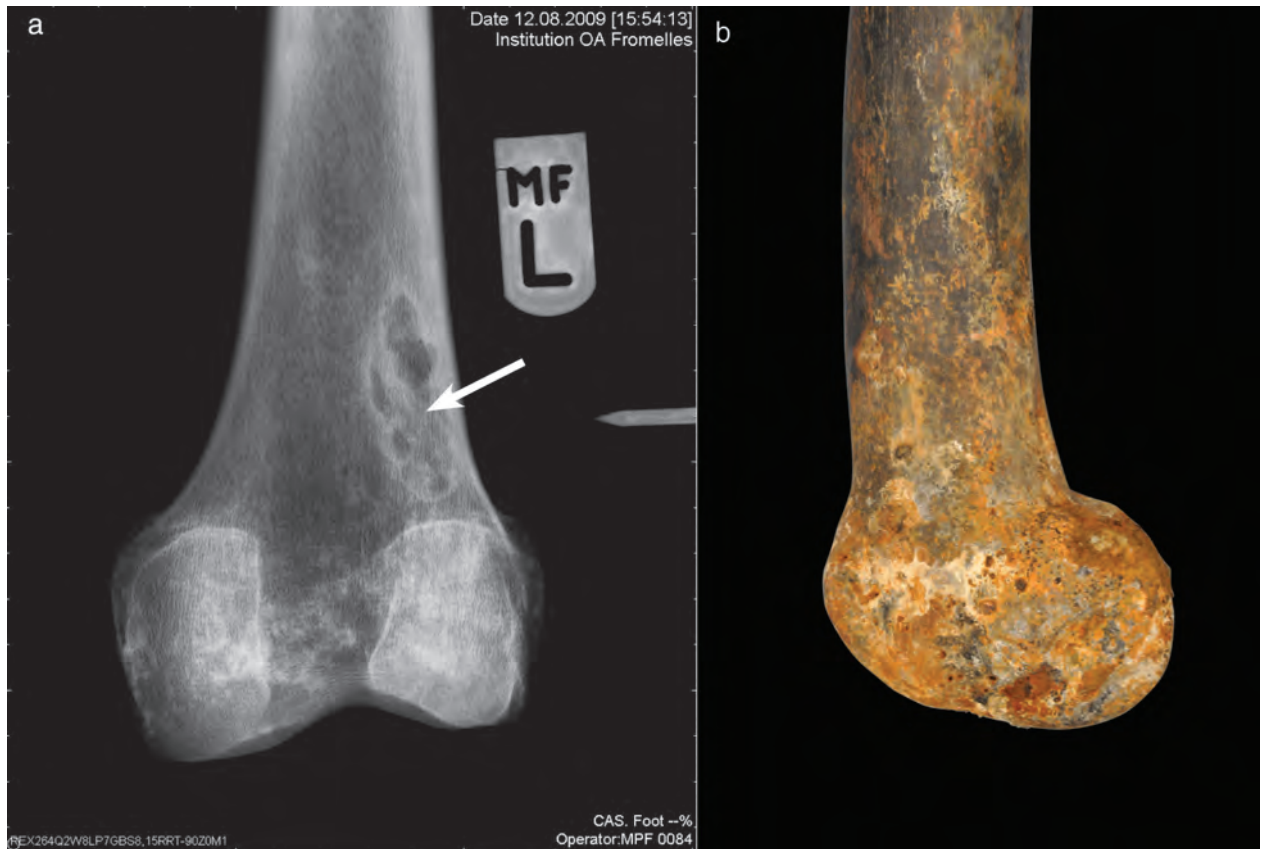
a) Radiograph showing fibrous cortical defect on left distal femur (1834B); b) macroscopic appearance of left distal femur with a marked absence of pathological change (1834B)
